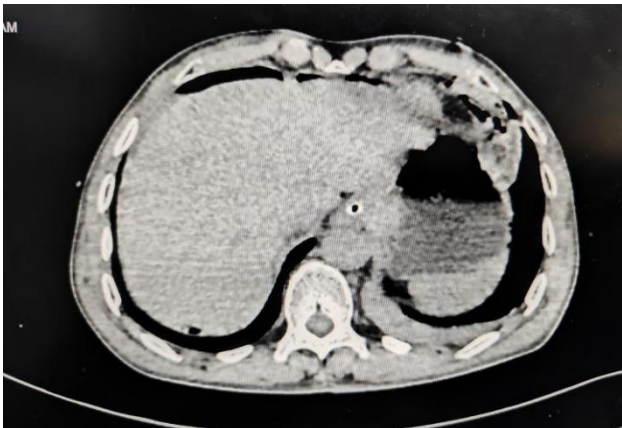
CT Abdomen plain revealing pneumoperitoneum.
